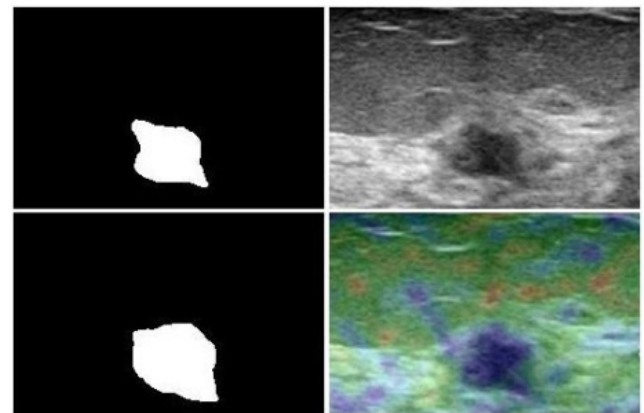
Image comparison of data Number 2; Ultrasound (top image, right), elastography (bottom image, right) and labels determined by the doctor (left images).
